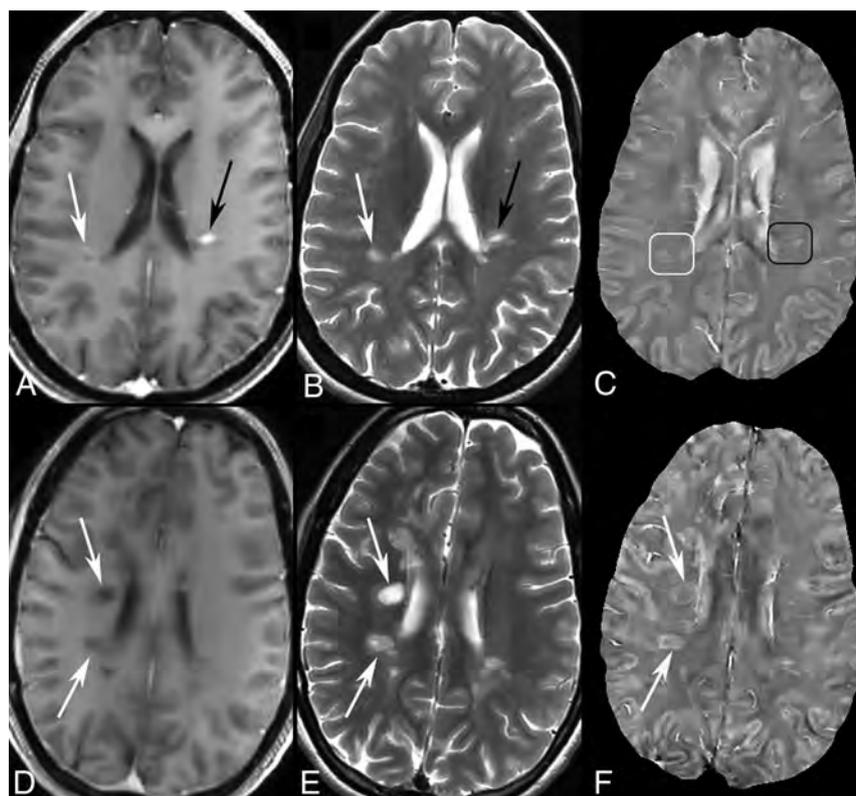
MR images of enhancing and nonenhancing new MS lesions. T1WI+Gd (A), T2WI (B), and QSM (C) in a 44-year-old woman with relapsing-remitting MS. Two enhancing lesions (A and B, arrows) are found in T1WI+Gd. One is shell-enhancing (A, white arrow) and another is nodular-enhancing (A, black arrow). The shell-enhancing lesion appears slightly QSM-hyperintense (C, white box) and the nodular one appears QSM isointense (C, black box). T1WI+Gd (D), T2WI (E), and QSM (F) in a 35-year-old woman with relapsing-remitting MS. Two new nonenhancing lesions (D and E, arrows) are found in T1WI+Gd and T2WI compared with MR imaging 6 months prior. The 2 lesions both appear QSM-hyperintense with bright rims (F, arrows).
